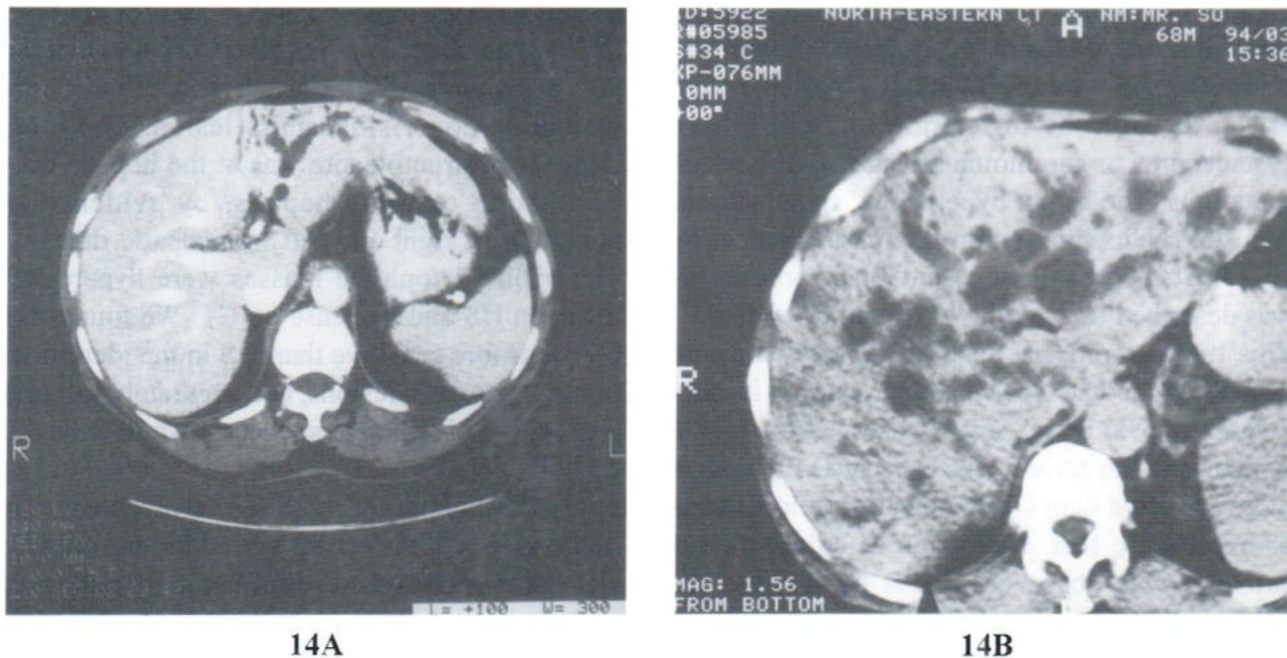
CT of extrahepatic type CHCA with non-visualized mass lesion
